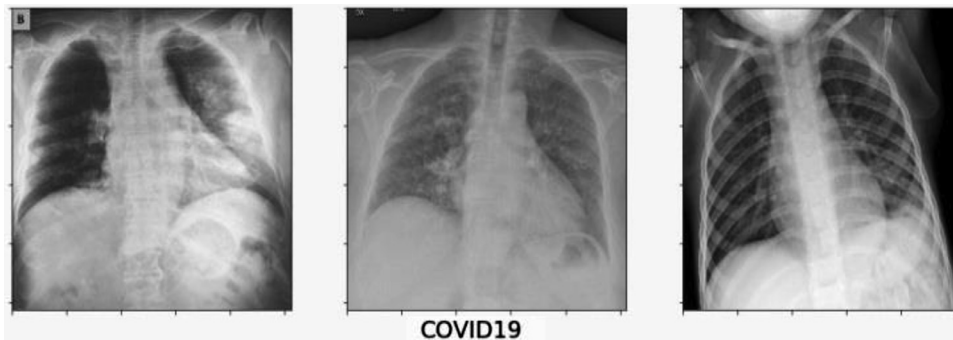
Corona positive chest X-ray images.
